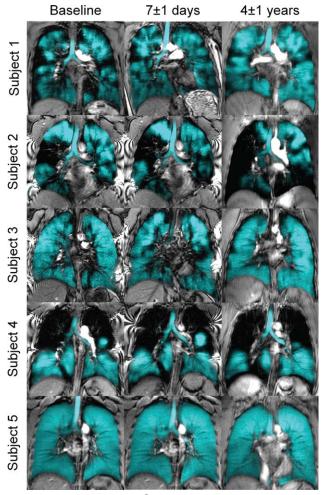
Hyperpolarized ³He MRI gas distribution for all subjects. Coronal center-slice ³He MRI (blue) coregistered to the corresponding anatomical ¹H MRI (gray) for all subjects and visits. Ventilation defect percent (VDP) for each subject at baseline, 7-day, and 4-year follow-up were: S1) 11, 9 and 11; S2) 25, 30, and 41; S3) 8, 7, and 4; S4) 34, 35, and 45; and S5) 1, 1, and 1.
